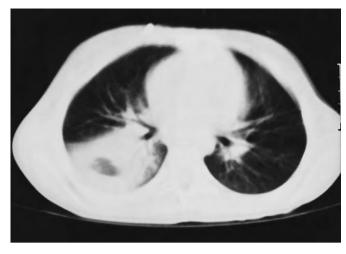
Computed tomography scan of the chest in a 6-year-old child with acute nonlymphocytic leukemia and aspergillosis in the right lower lobe.
